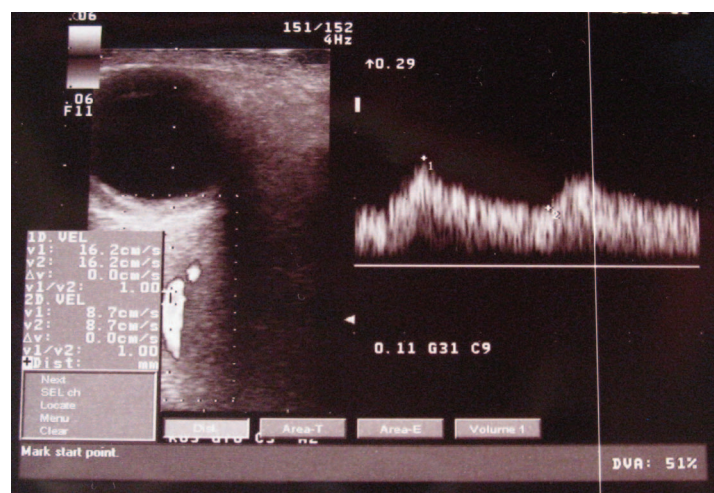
Color Doppler imaging shows enlarged superior ophthalmic vein (SOV) on the right side with reversed flow. Spectral Doppler analysis confirms the arterialized flow with a peak systolic velocity (PSV) of 16.2 cm/s.
